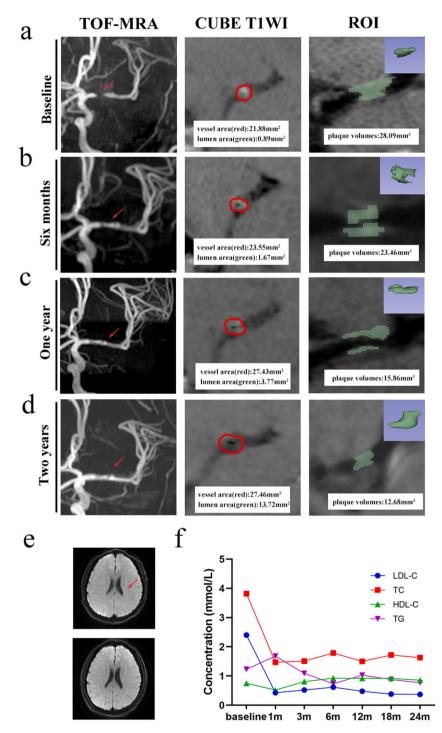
Changes in the MRI and level of blood lipid. (a) The MRA images at baseline. The stenosis at M1 segment of left MCA was shown (red arrow). The vessel area and lumen area of the stenosis was 21.88 mm² and 0.89 mm². The plaque volumes were 28.09 mm³. (b) The MRA images at sixmonth follow up. The stenosis at M1 segment of left MCA was improved (red arrow). The vessel area and lumen area of the stenosis was 23.55 mm² and 1.67 mm². The plaque volumes were 23.46 mm³. (c) The MRA images at one-year follow up. The stenosis at M1 segment of left MCA was improved (red arrow). The vessel area and lumen area of the stenosis was 27.43 mm² and 3.77 mm². The plaque volumes were 15.86 mm³. (d) The MRA images at two-year follow up. The stenosis at M1 segment of left MCA was further improved (red arrow). The vessel area and lumen area of the stenosis was 27.46 mm² and 13.72 mm². The plaque volumes were 12.68 mm³. (e) The DWI sequence at baseline (upper image) and two-year follow up (lower image). A small left basal ganglia infarction was seen on baseline image (red arrow). (f) The line chart of blood lipid at baseline, 1-month, 3-month, 6-month, 12-month, and 24-month follow up.
